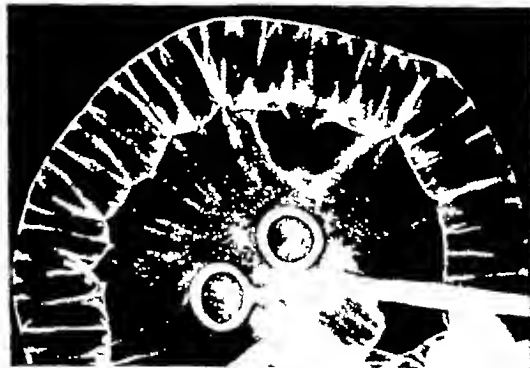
Photograph of contrast X-ray study of portion of jejunum of Case 3 Note the valves and relatively small ostium of the large diverticulum
